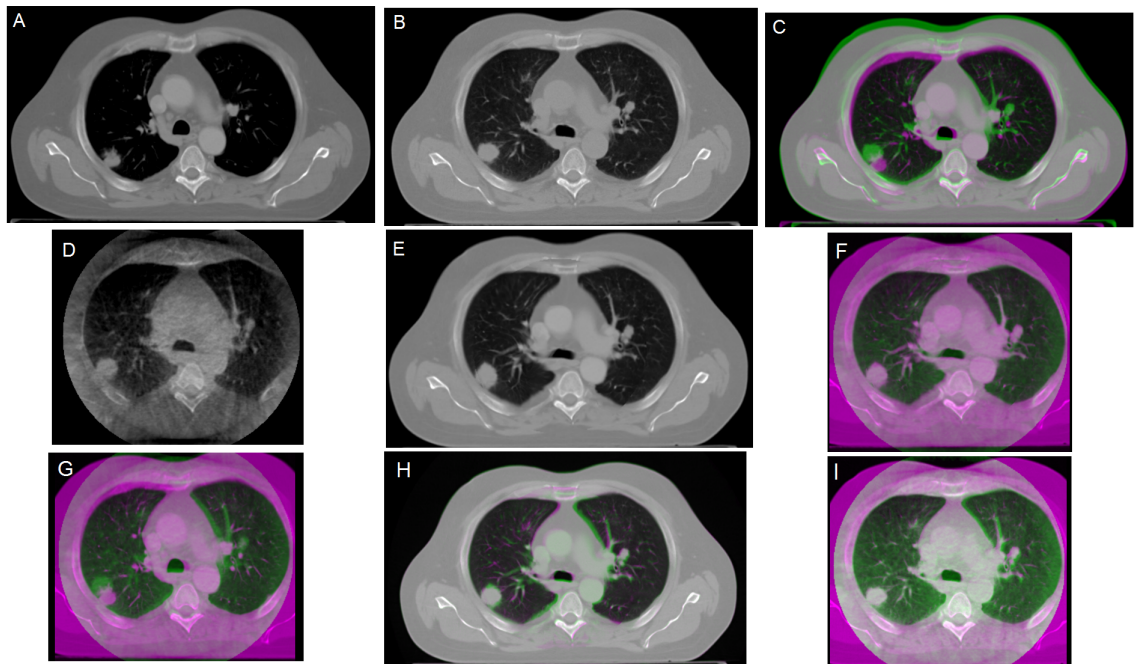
The four scans of Patient A: planning CT (A), repeat CT (B), CBCT (D) and mCT (E). And overlays of scans for better visualization: planning CT (purple) and repeat CT (green) (C), mCT (purple) and CBCT (green) (F), planning CT (purple) and CBCT (green) (G), repeat CT (purple) and mCT (green) (H), and repeat CT (purple) and CBCT (green) (I)
